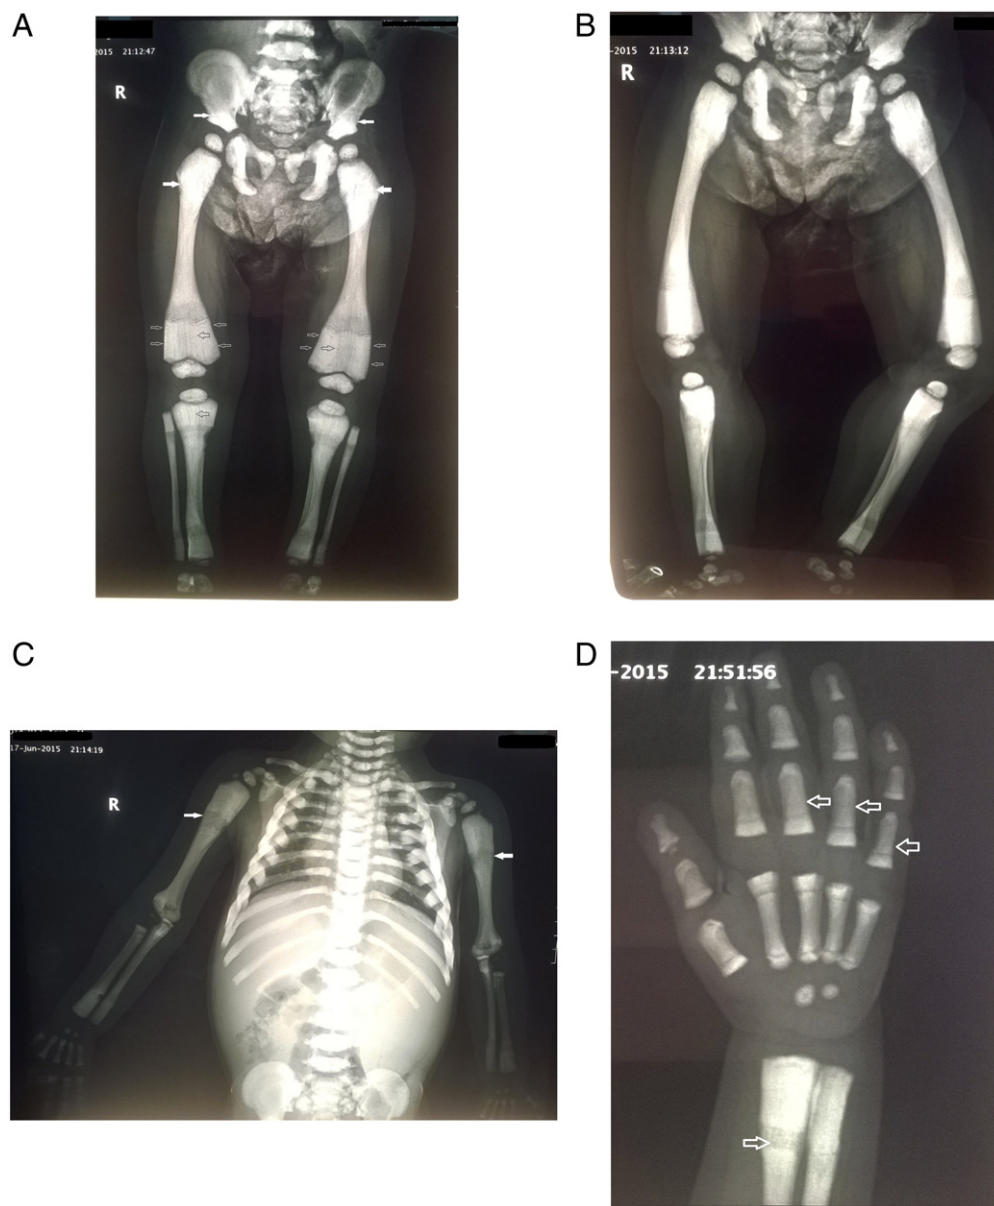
Radiographs showing antero-posterior (A) and lateral views (B) of the pelvis and both lower limbs. Antero-posterior view of the chest wall and both upper limbs (C) and left hand (D). Note the uniform sclerosis of the pelvis and long bones of the lower limbs (A, B) long bones of the upper limbs (C) and short tubular bones (D). The classic “bone-within-bone” appearance is recognizable in the pelvis and proximal femora (white arrows) (A) and upper limbs (white arrows) (C) and short tubular bones of the hand (hollow arrows) (D). Note the Erlenmeyer flask deformity type 2 which is characterized by absence of normal diaphyseal metaphyseal modelling of the distal femora with abnormal radiographic appearance of trabecular bone (hollow white arrows) and alternating radiolucent metaphyseal bands (hollow black arrows) (A).
